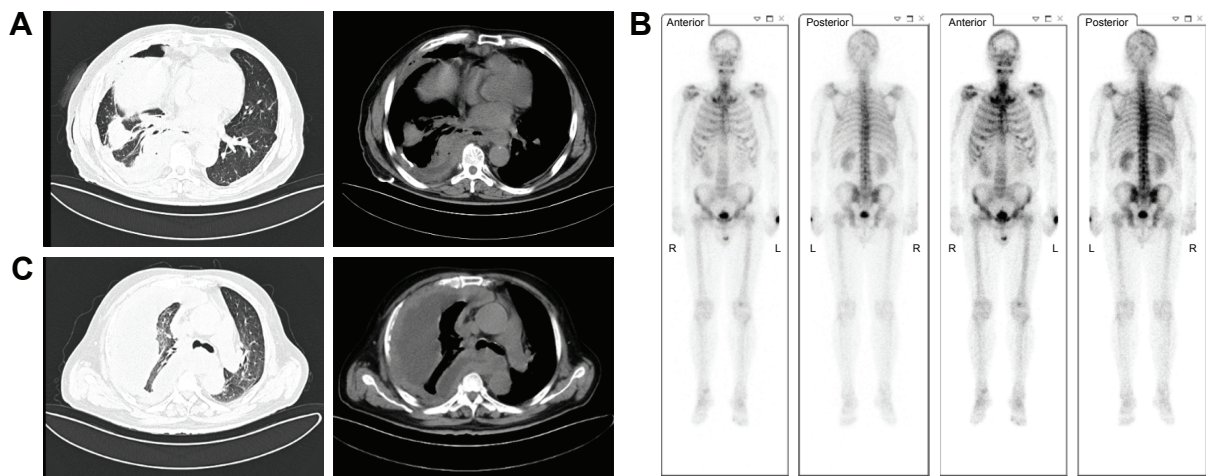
Images of CT and SPECT. (A) CT image. After thoracoscopy, most pleural effusion was drained. CT revealed spot- and piece-shaped shadows, showing multiple solid lesions in the right lung. (B) SPECT image. General bone scan showed multiple metabolic abnormalities and concentration points. (C) CT image. Pleural effusion increased further, and the pleura became much thickened with multiple nodules.
